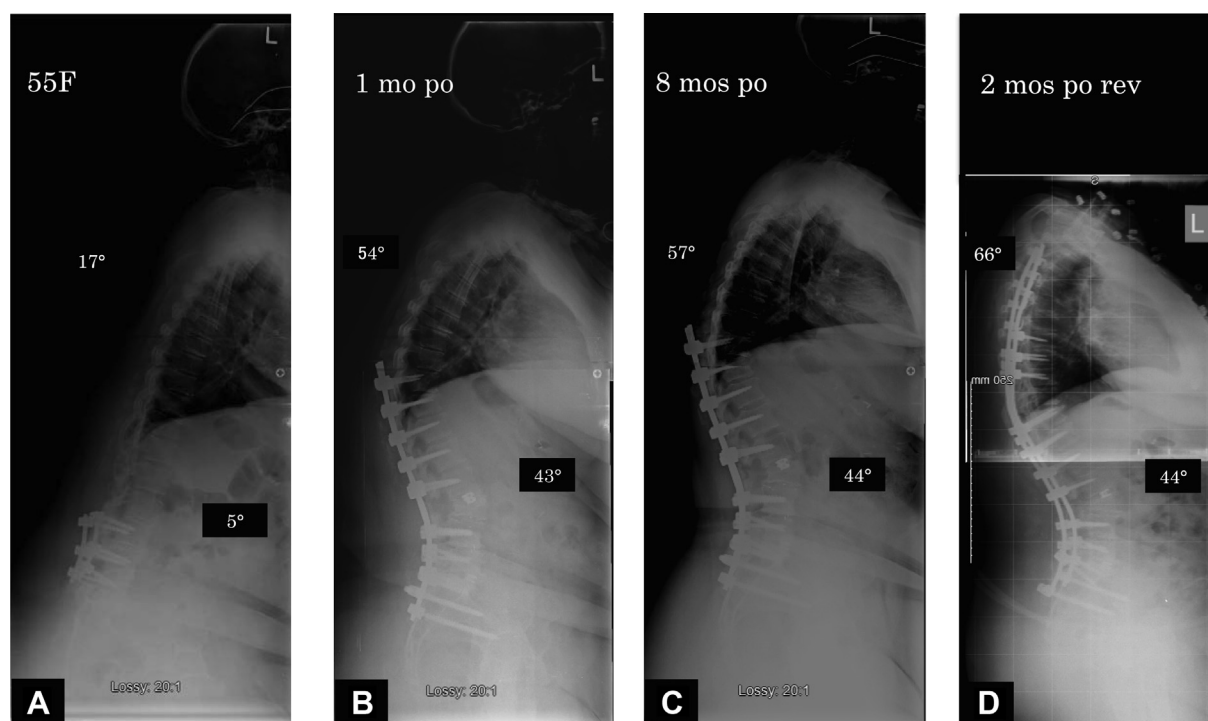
(A) Lateral full-length views of a 55-year-old woman with a history of five-level lumbar decompression and fusion, with persistent complaints of low back pain, sciatica, and sagittal imbalance. She had a history of cervical surgery for cervical myelopathy. (B) Standing lateral radiograph was performed one month after posterior spinal fusion from T10 to pelvis. (C) Standing lateral radiograph 8 months after index surgery showing that proximal junctional kyphosis increased to 18° with 57° of thoracic kyphosis and 44° of lumbar lordosis. (D) Standing lateral radiograph at 2 months after revision surgery for PJF.
